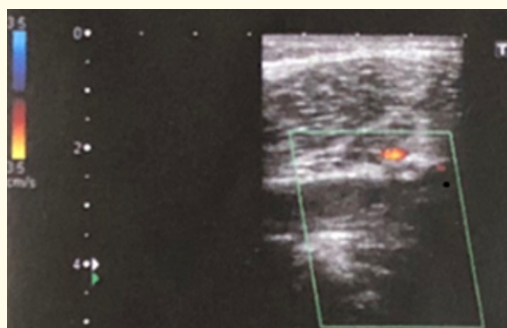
Eco-Doppler of lower limbs showing the enhanced diameter of the right fibular vein without blood flow, and the presence of ecogenic material within the venous lumen.
